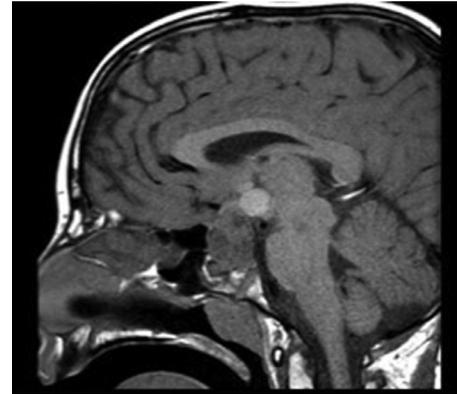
Preoperative MRI T1 postcontrast image showing a sagittal section demonstrating a large, heterogeneous and partially cystic mass, centered around the sella. This appearance is characteristic of craniopharyngioma. MRI, magnetic resonance imaging.
